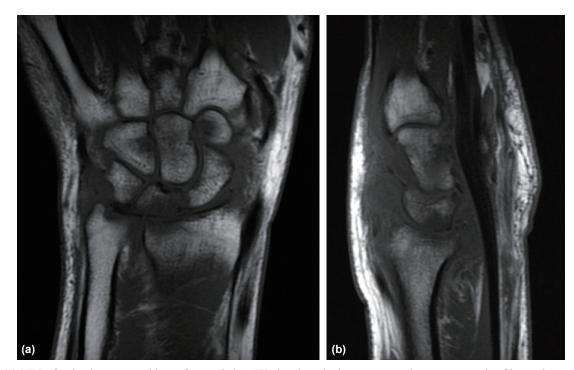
(a) MRI of wrist demonstrated loss of normal short T1 signal on the lunate, suggesting osteonecrosis of lunate bone. (b) MRI of wrist demonstrated loss of normal short T1 signal on the lunate, suggesting osteonecrosis of lunate bone.
